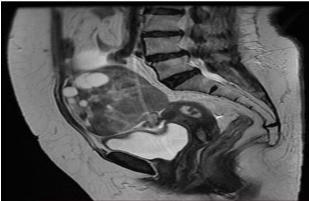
(A and B): MRI revealing an enlarged right ovary with predominantly solid lesion 15.2×11.2×8.5 cm predominantly solid lesion with multiple variable sized cystic areas noted midline in the pelvis. Solid components of the lesion show T1 hypointense T2 heterogenously hyperintense areas, postcontrast enhancement and diffuse restriction. Solid components of the lesion show T1 hypointense T2 heterogenously hyperintense areas, postcontrast enhancement and diffuse restriction. Relatively largest cystic component 75×6.9×7.8 cm noted in the superior aspect of the lesion.
